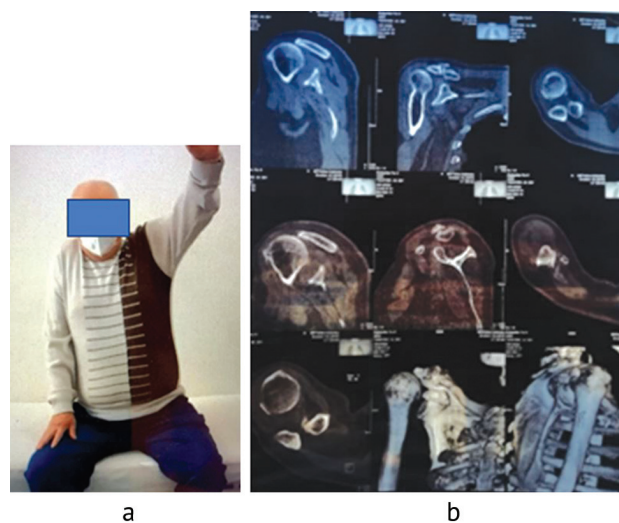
Patient trying to perform active movements (a) and CT findings (b)
